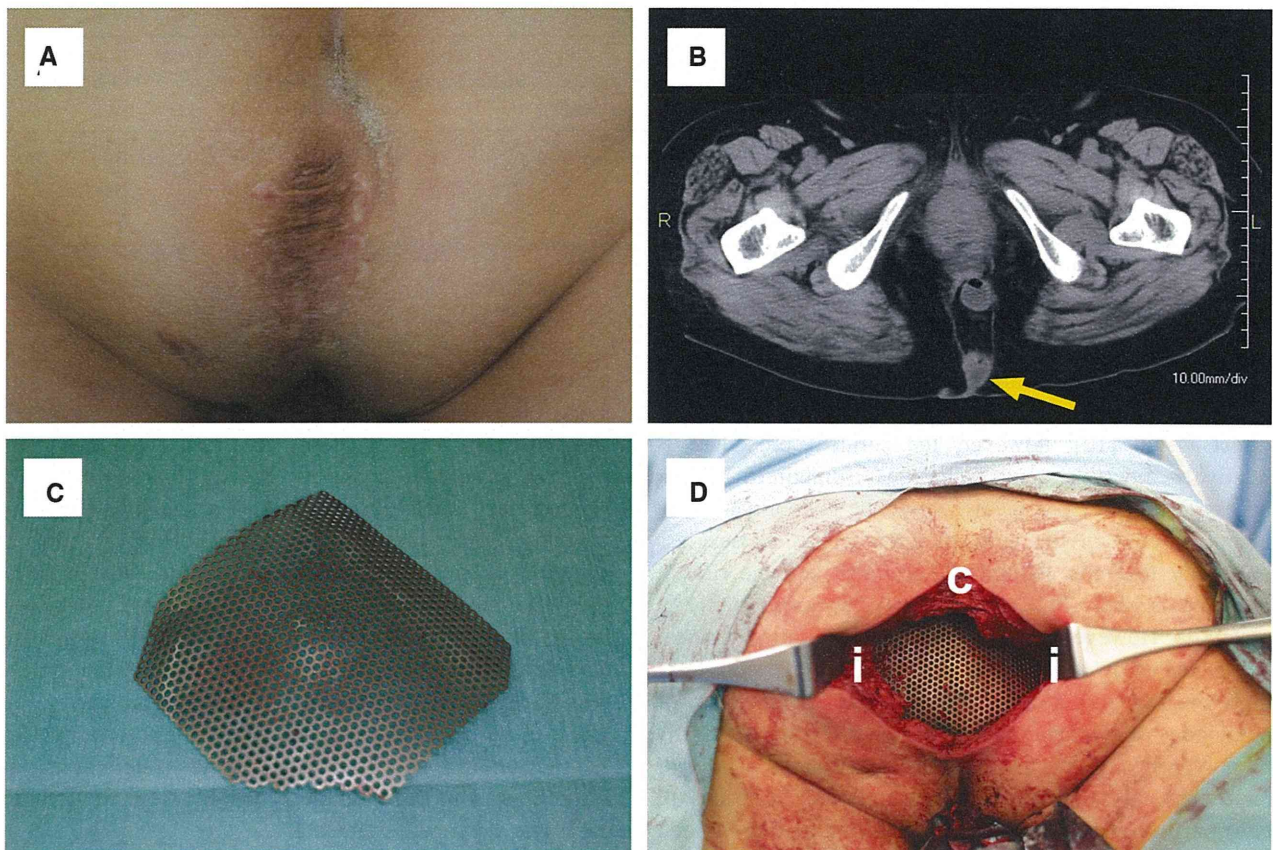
A Preoperative image (“Case 1”). The patient suffered painful bulging in the perineal region. B Preoperative computed tomography scan revealed a herniation of the small bowel protruding into the perineum (*arrow*). Reproduced from Ref. [18] with permission. C A thin titanium mesh was molded intraoperatively to measure
